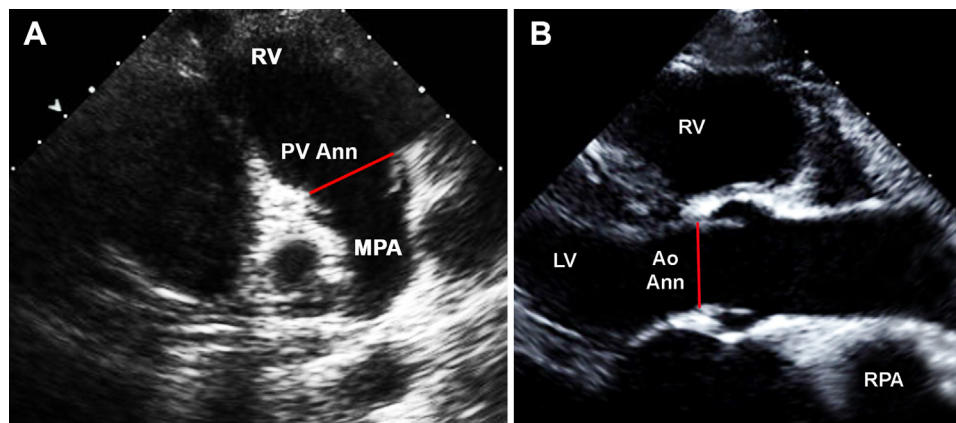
Aortic valve and pulmonary valve (PV) annular diameter measurements during maximal valve opening in early to mid-systole: (A) PV annular diameter from the parasternal long-axis view with anterosuperior tilting and (B) Aortic valve annular diameter from the parasternal long-axis view. Reproduced with permission from Lopez *et al.*² Ann, Annulus; Ao, aortic; LV, left ventricle; MPA, main pulmonary artery; RPA, right PA; RV, right ventricle.
